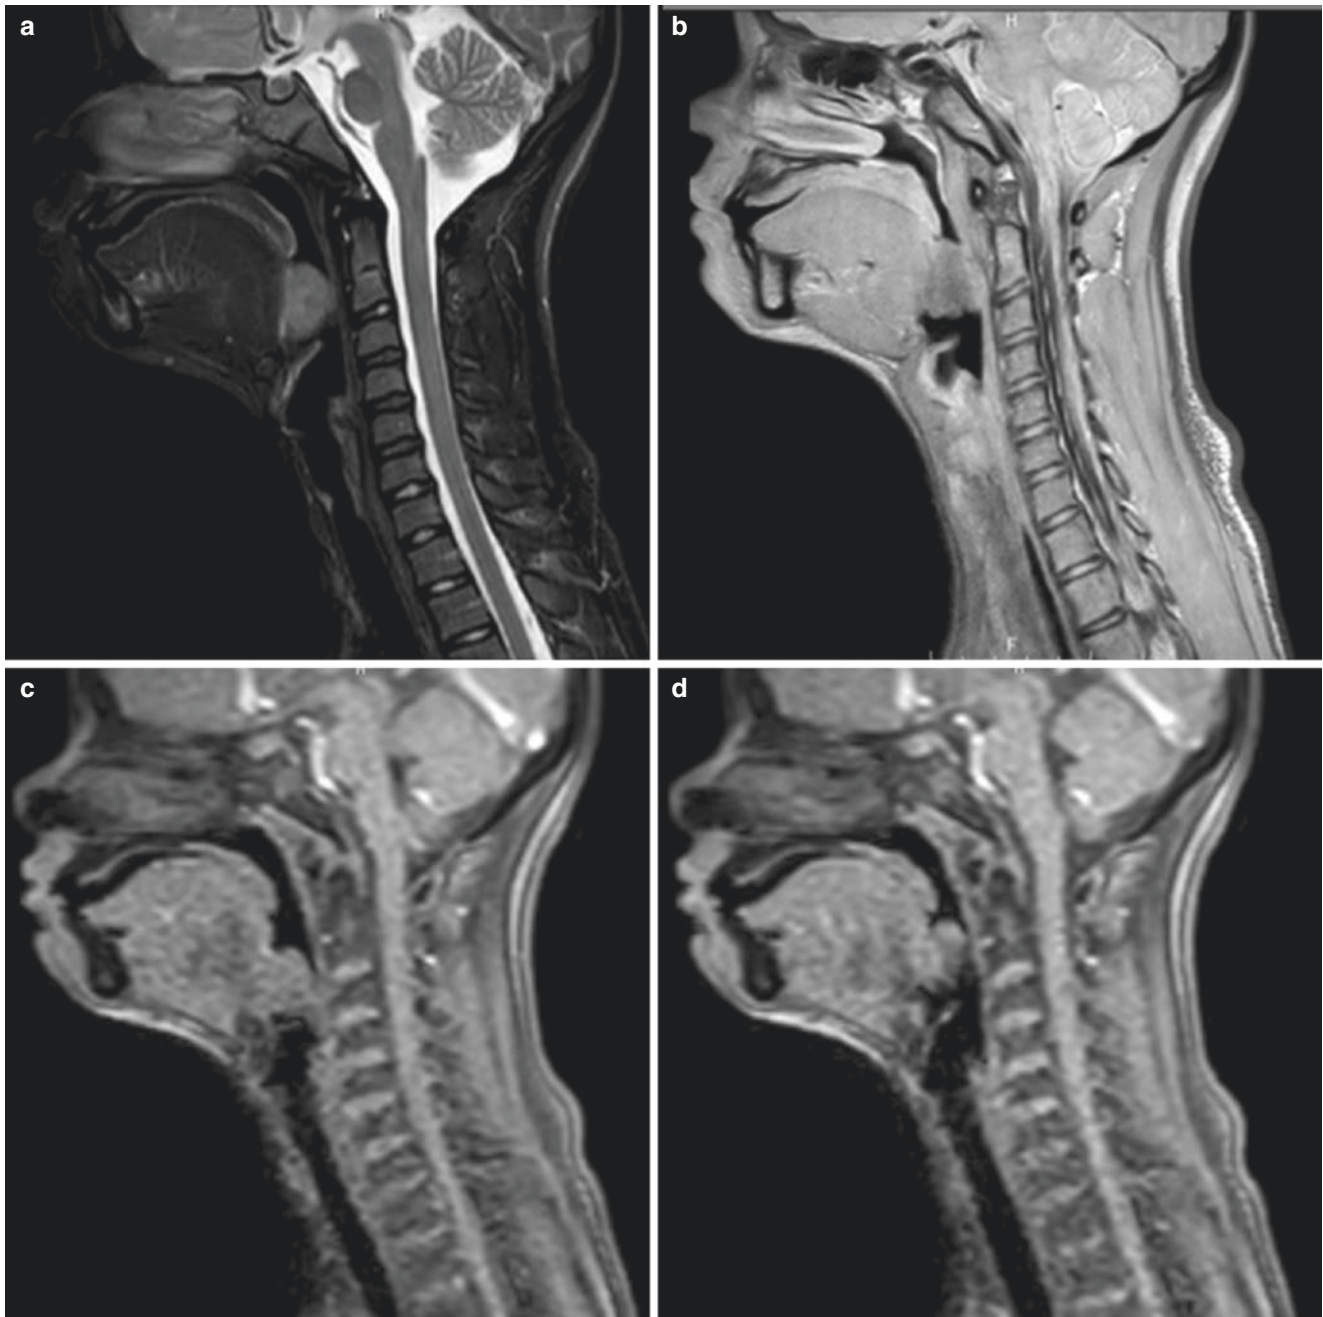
Sagittal cine MRI of the upper airway. This MRI demonstrates lingual tonsillar hypertrophy in both T2 (a) and T1 images (b). It also demonstrates dynamic obstruction from lingual tonsils during inspiration (c) and expiration (d)
